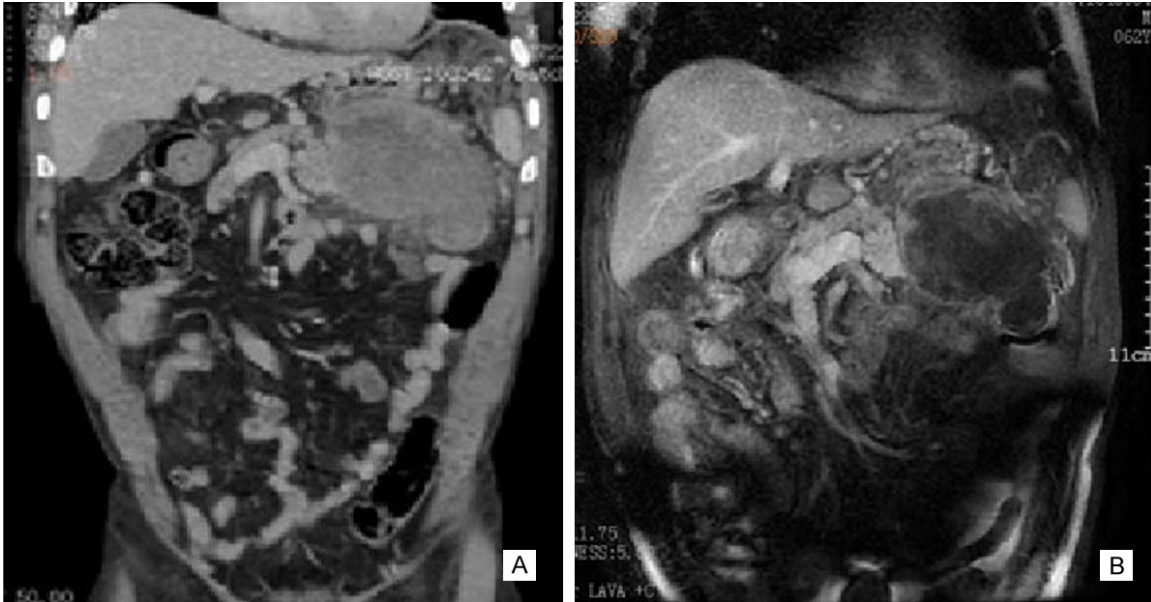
A. Abdominal plain and CTA (256) imaging data. B. Enhanced MRI of the upper abdomen.
